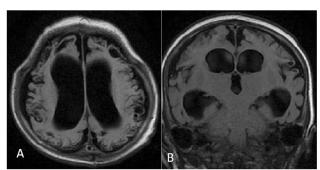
A 5-month-old preterm male infant underwent MRI scan for the complaints of seizures (A) axial and (B) coronal FLAIR images reveals extensive bilateral areas of cystic encephalomalacia with moderate dilatation of ventricles.
